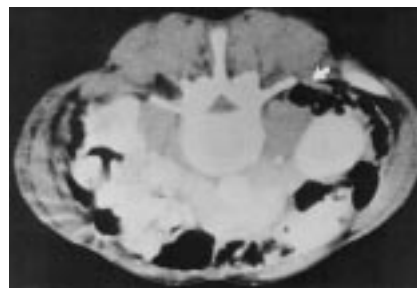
Abdominal computed tomographic scan. Arrow indicates markedly displaced colon insinuating itself behind the psoas muscle; clearly, a posterolateral approach could perforate the bowel. (Reproduced with permission from Onik G, Helms C (eds): *Automated Percutaneous Lumbar Discectomy*. San Francisco, Radiology Research and Education Foundation, 1988, p 78.)
